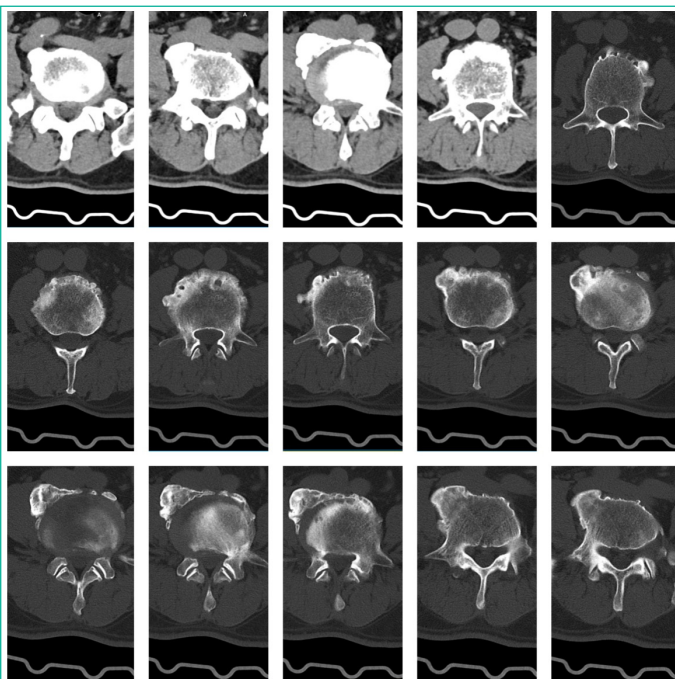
CT cross-sectional imaging of the lumbar spine revealed severe osteochondral lesions within the lumbar vertebrae.
